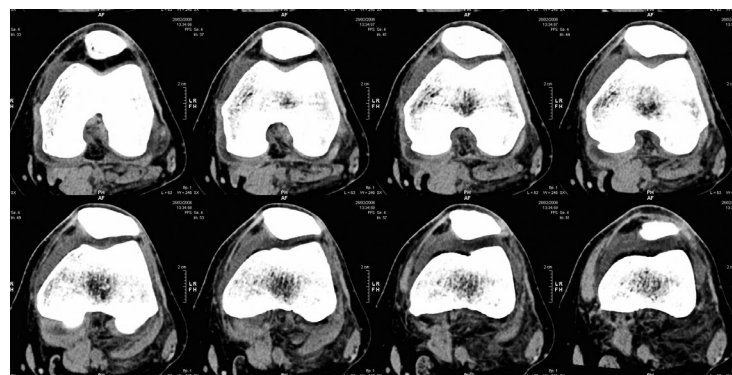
Computed axial tomography study (CT) scan of the knee taken prior to surgery to assist with surgical planning.
